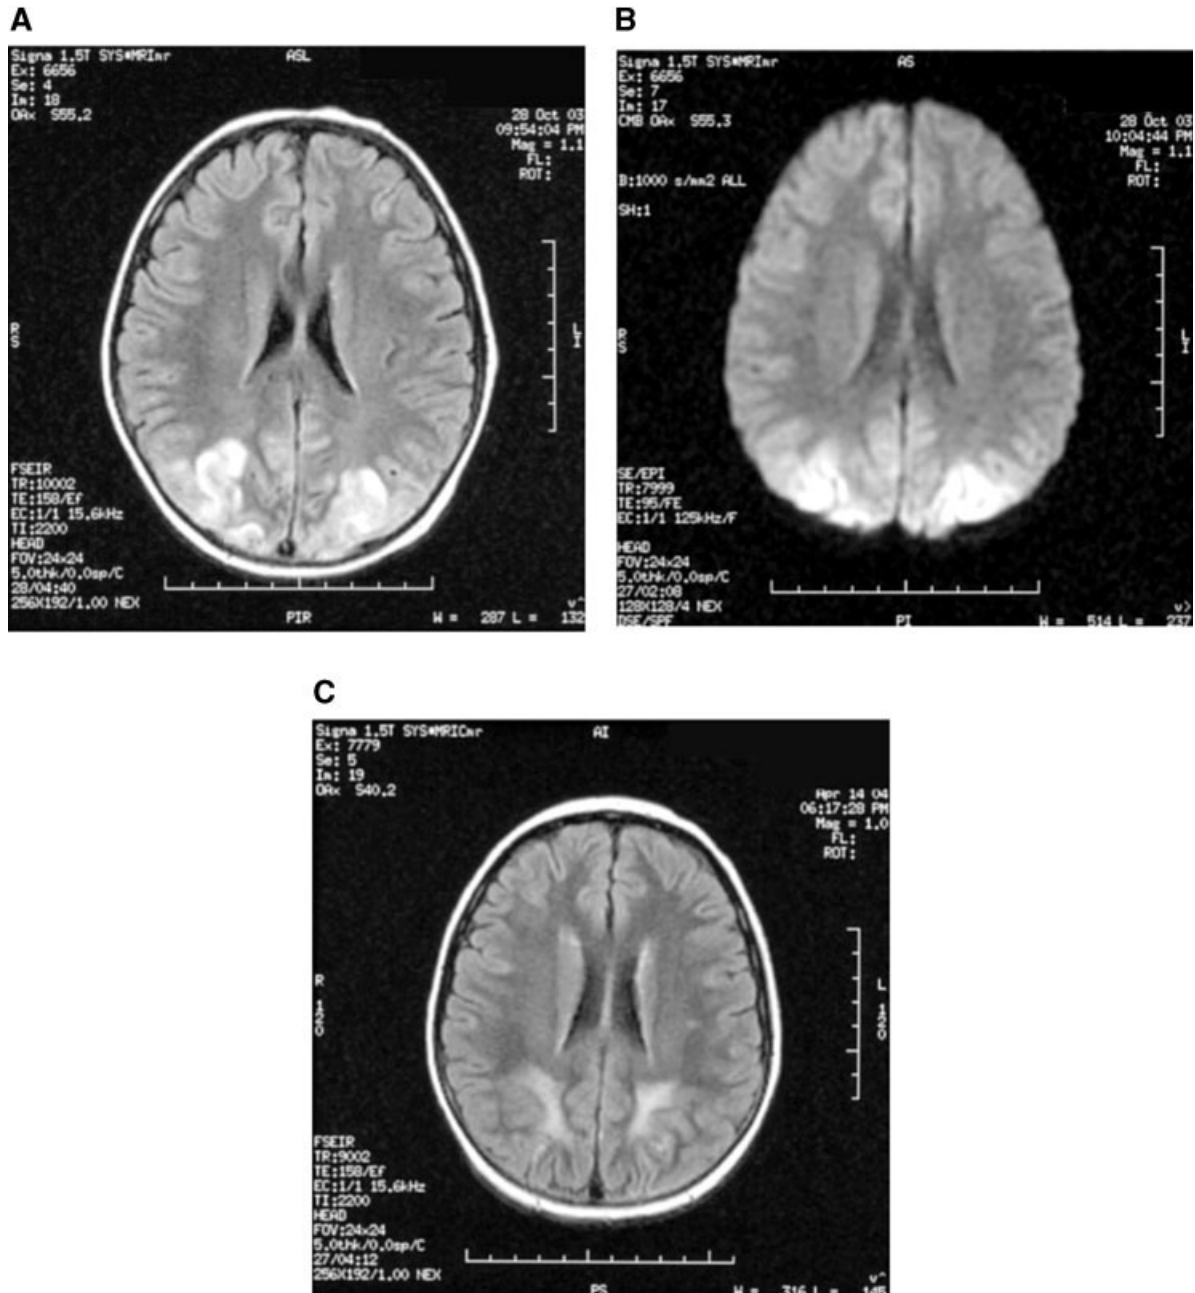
(MRI images): A: Initial T2-weighted FLAIR image showing T2-signal abnormalities in bilateral parietal and occipital gray matter. B: Initial diffusion weighted image that has some T2 shine-through, but is otherwise normal. C: Follow up T2 weighted FLAIR image at 6 months showing gliosis in the temporal, parietal, and right frontal regions.
